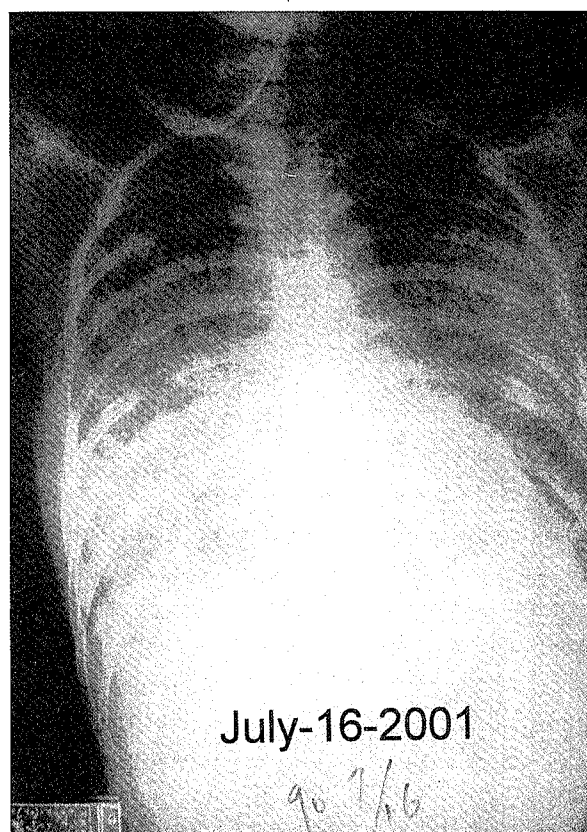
The chest roentgenogram reveals diffuse bilateral infiltrations with air bronchograms in the secondary respiratory failure. Disseminated cryptococcosis with ARDS was finally diagnosed.
